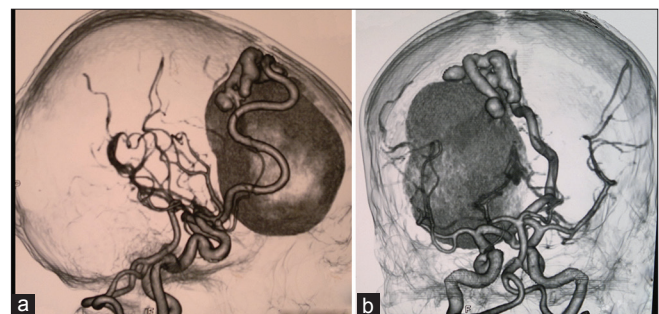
128 Multi slice cerebral computed tomographic angiography sagittal (a) and coronal (b) view demonstrates a large left frontal arteriovenous fistula supplied by the distal left anterior cerebral artery draining through a dilated cortical vein into the superior sagittal sinus. A large variceal dilatation of the proximal venous end measuring nearly 6.5 cm in diameter with wall calcification is shown in association with the arteriovenous fistula
